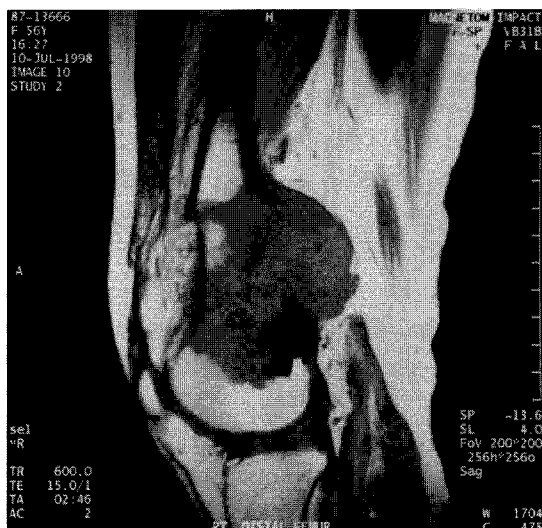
T1 weighted MR image shows a huge soft tissue mass of heterogeneous signal intensity.
